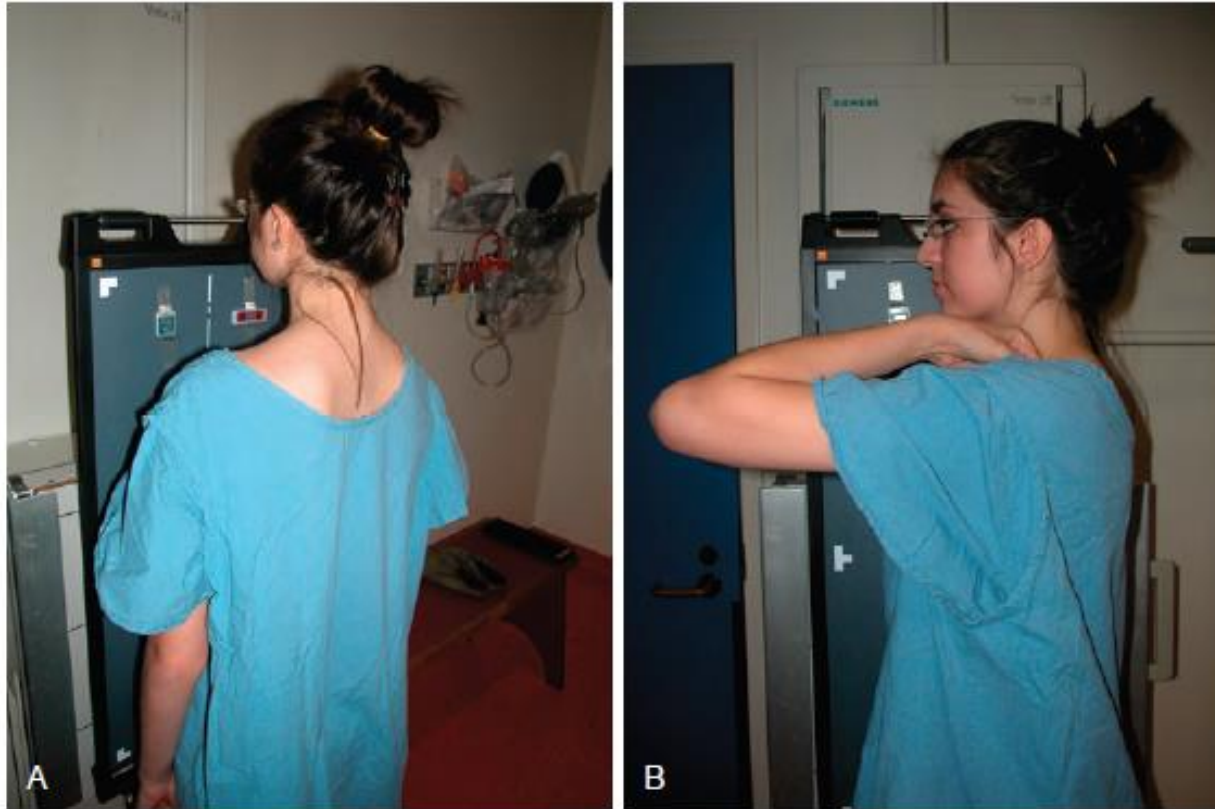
During radiographic evaluation the patient stands erect with the knees straight and the feet together. The posteroanterior projection (A) reduces exposure to breast tissue. During the lateral view (B), the arms are held forward to allow clear visualization of the spine.
